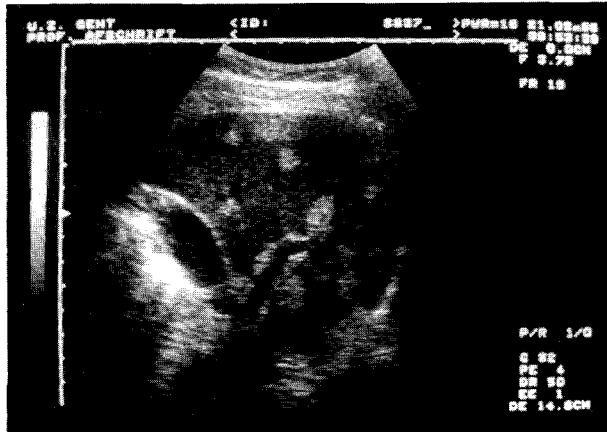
Ultrasound of the liver : Multiple hyperechogenic lesions.
